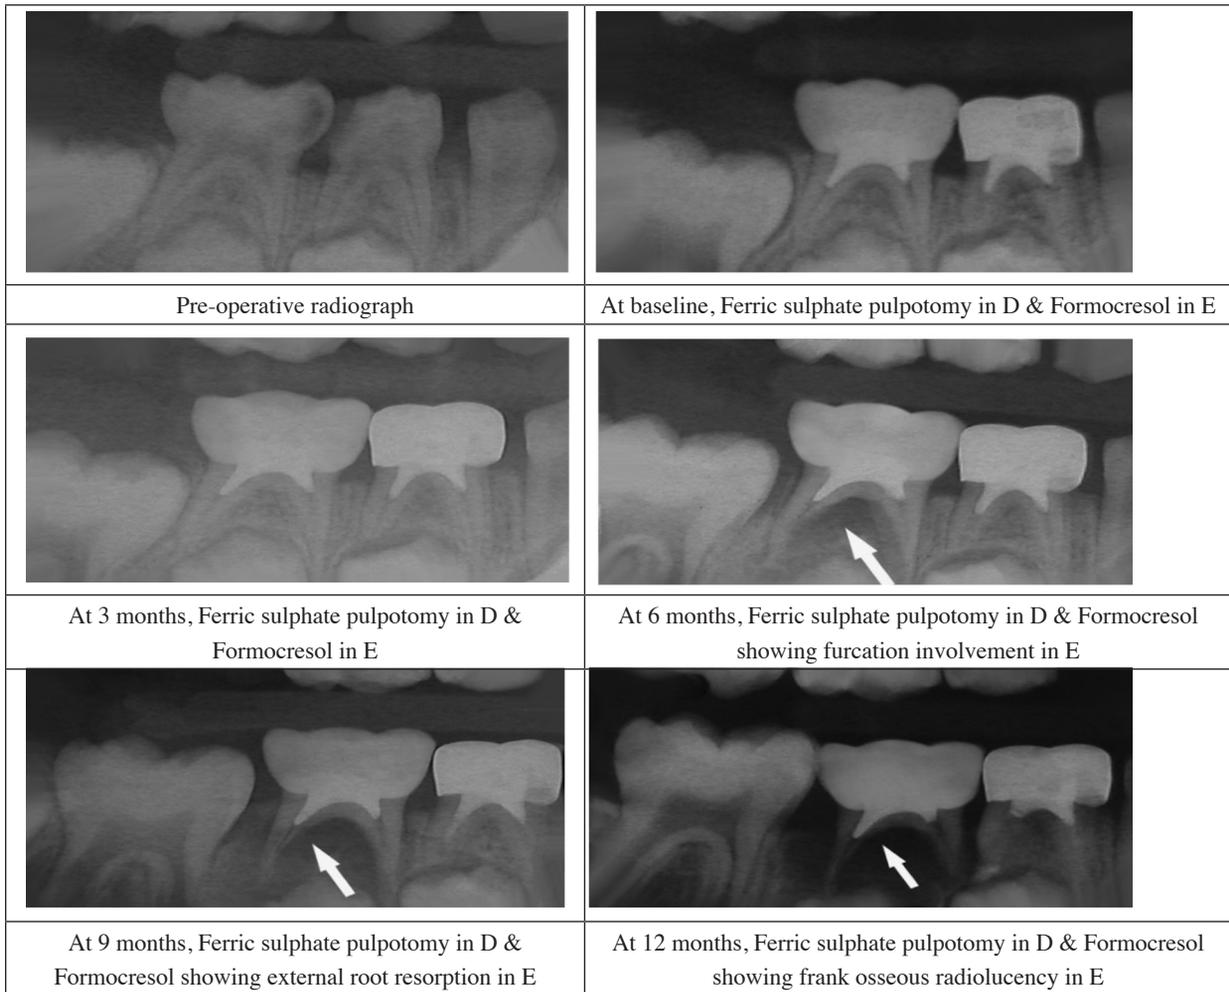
Radiographs of Formocresol and ferric sulphate pulpotomy at different time intervals
